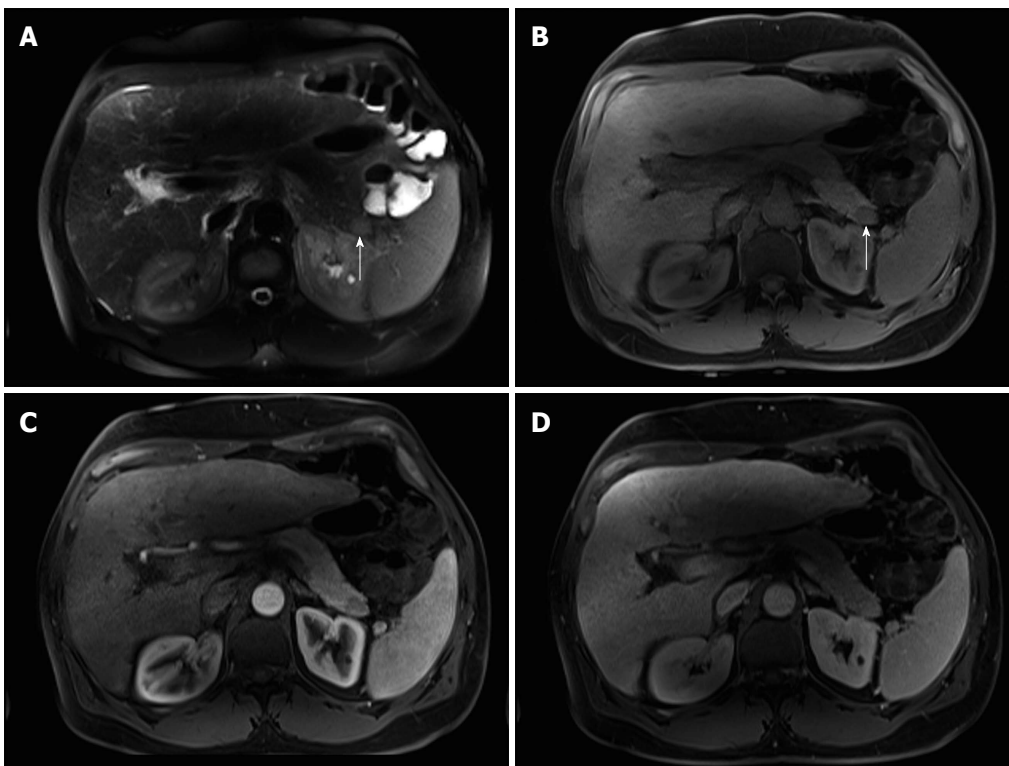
Intra-pancreatic splenule. Axial T2-weighted SS-ETSE (A), pre-contrast fat-suppressed T1-weighted (B) GRE and post-gadolinium fat-suppressed T1-weighted GRE images acquired in the arterial (C) and venous (D) phases of enhancement. There is a well-margined and lobulated round intra-pancreatic splenule (arrows, A and B) that shows isointense signal to the pancreas on T2- and T1-weighted images (A and B). This nodule is hypointense compared to the background pancreas on the precontrast T1-weighted image (B) and demonstrates lesser enhancement relative to the pancreas on the arterial phase (C) and hepatic venous phase (D). The enhancement pattern was homogenous on the postgadolinium images and similar to that of the pancreas. SS-ETSE: Single-shot echo train spin echo; GRE: Gradient echo.
